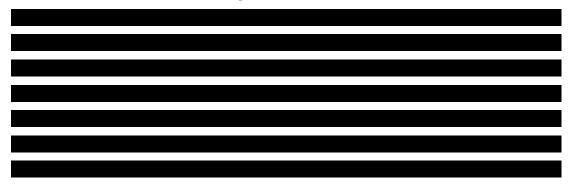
Abbreviations: CS, company submission; ECHO: LV-SF, echocardiogram: left ventricle–systolic function; GFR, glomerular filtration rate; IL-2, interleukin-2; pgs, pages; SGOT, serum glutamic-oxaloacetic transaminase (= AST); SGPT, serum glutamic pyruvic transaminase (= ALT); WBC, white blood cells.
